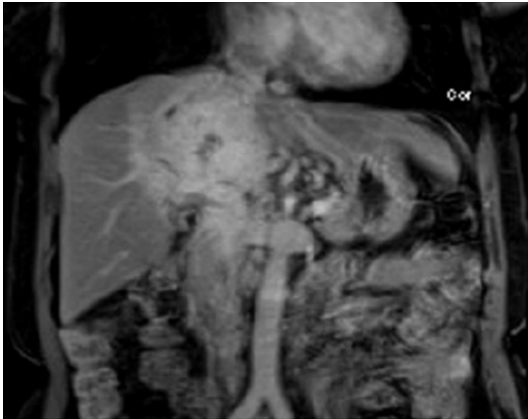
An MRI showing a large tumor located in the right liver that was close to the inferior vena cava (IVC).
